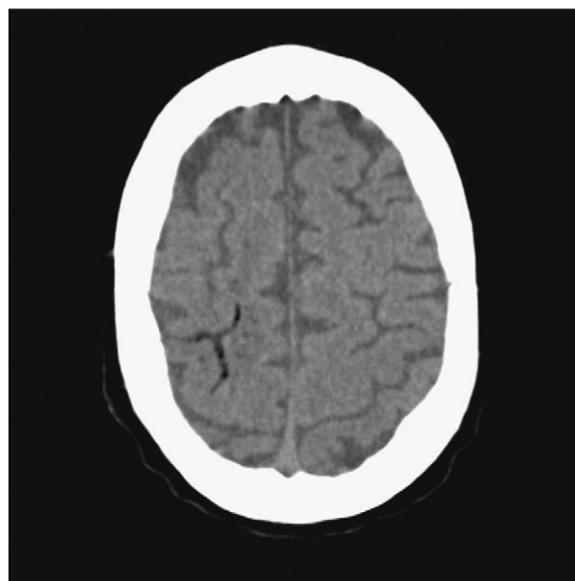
Brain CT scan performed 1 h after the onset of symptoms. Serpiginous images with air density in the parietal cortical area.
